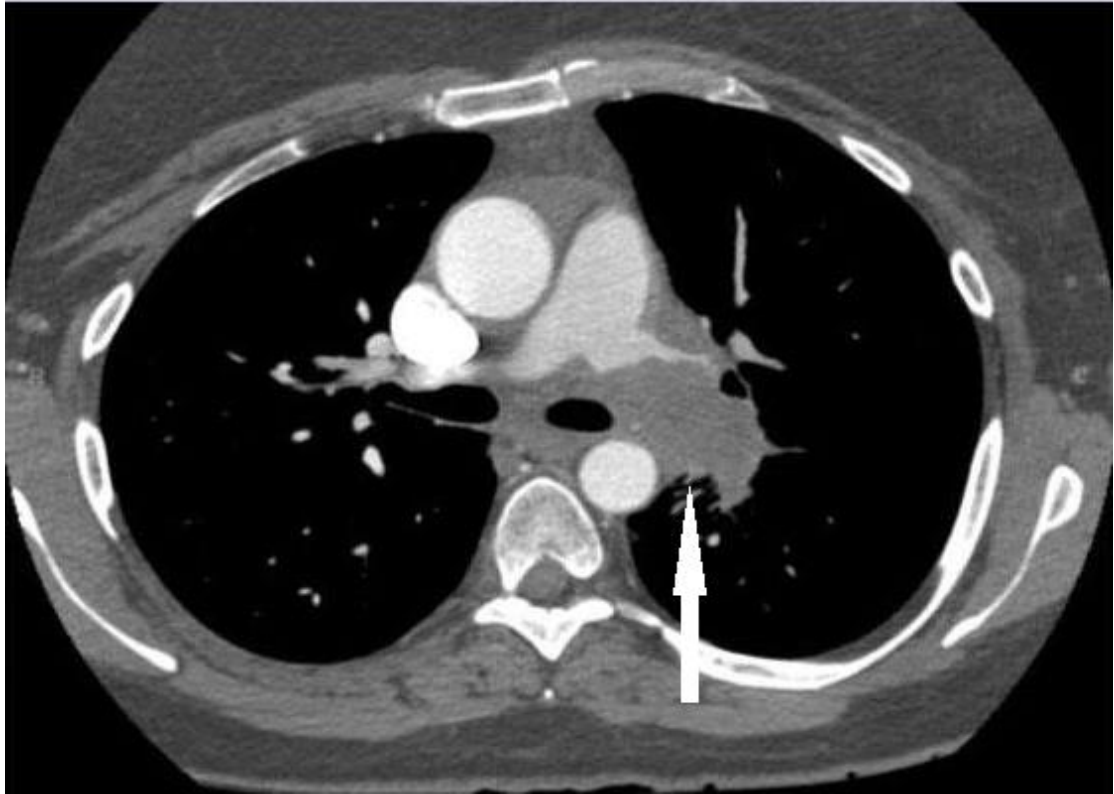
A 42 year's male axial CT image of the chest demonstrating acute massive pulmonary embolism in the left main pulmonary artery and extending into all subbranches
